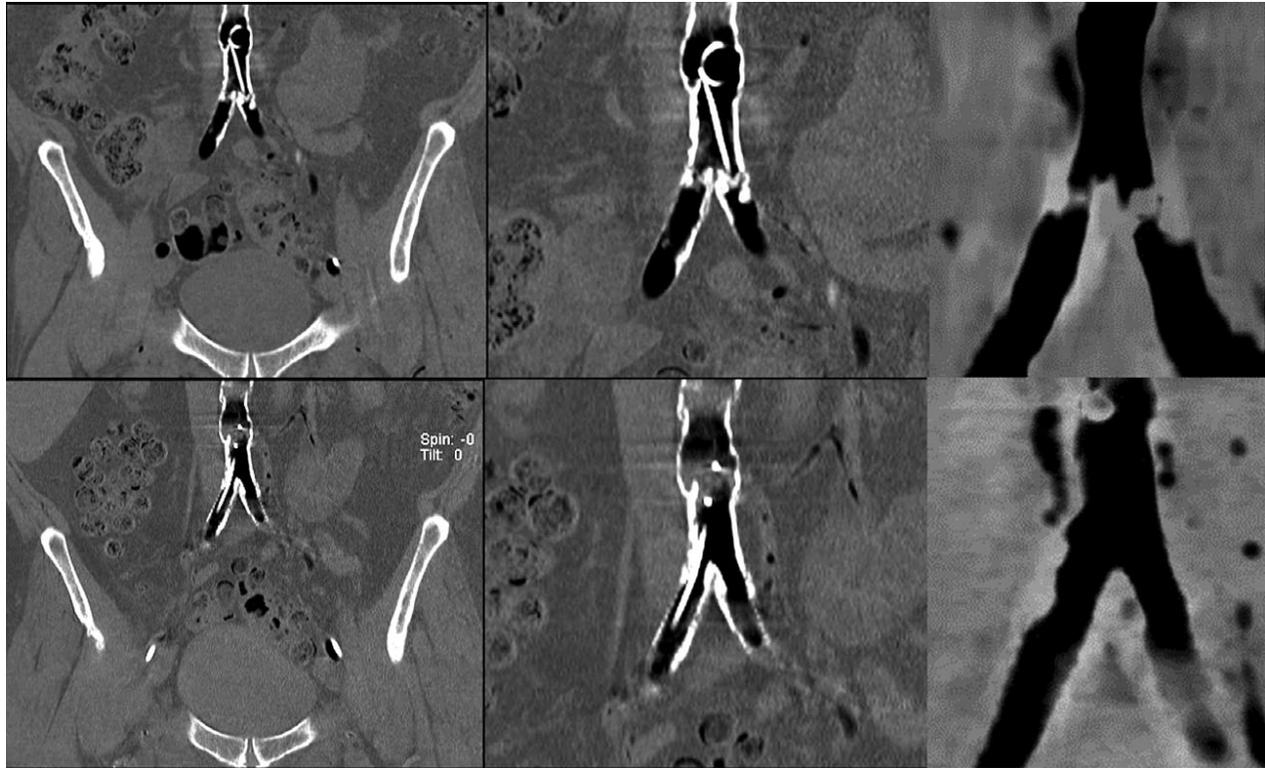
Coronal CO₂CTA MPR and MINIP imaging demonstrating bilateral iliac stenosis pre (top row) and post treatment (bottom row).
